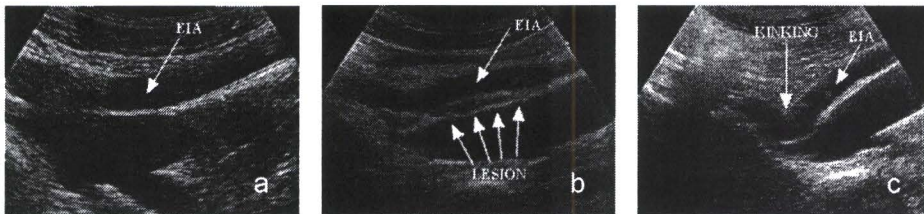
Examples of images made with ultrasound from (a) a healthy artery, (b) an artery with a stenotic lesion and (c) an artery with severe kinking. EIA is external iliac artery [5].
